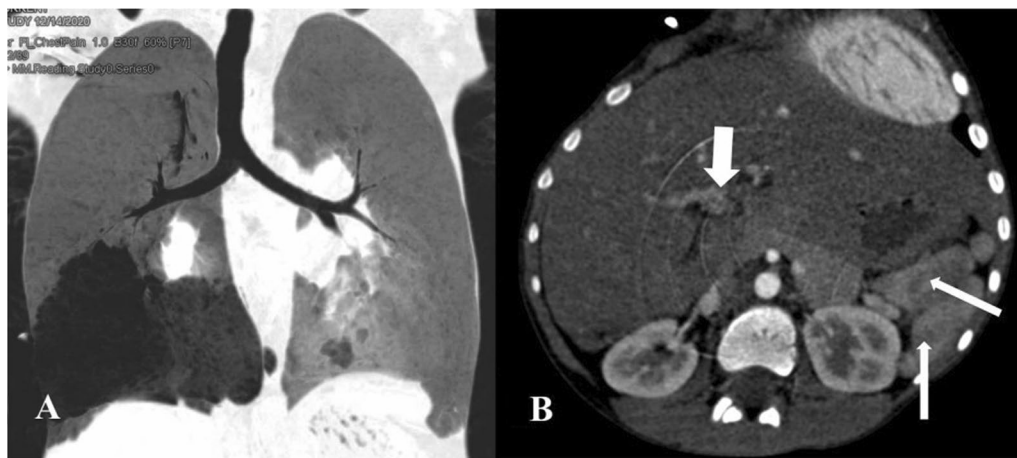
Contrast CT images in lung (A) and mediastinal (B) windows show bilateral hyperarterial bronchi with midline transverse liver, polysplenia (thin arrows) and preduodenal portal vein (thick arrow)
